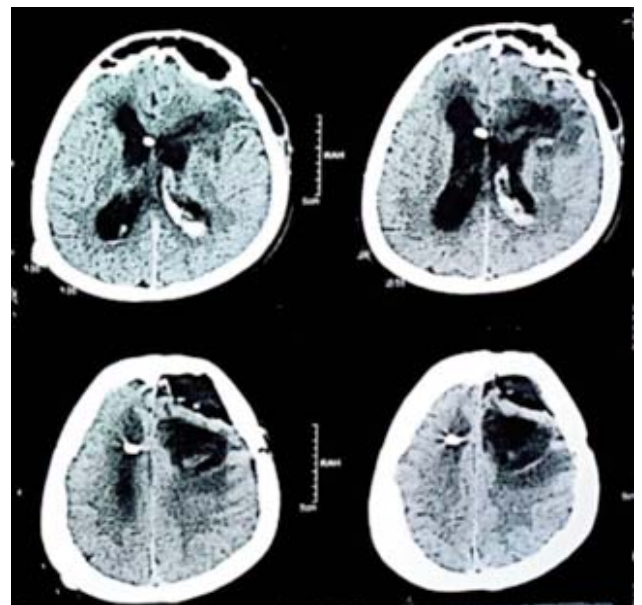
Post-drainage CT scan showing external ventricular drain in-situ, left lateral ventricular haemorrhage, dilated lateral ventricles and aerocoel.
